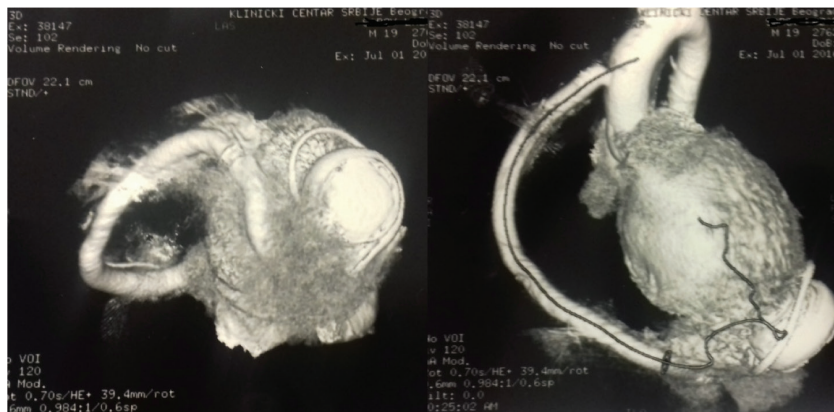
Multi-slice computed tomography finding – outflow cannula with the aorta and the inflow cannula with the left ventricle were competent
